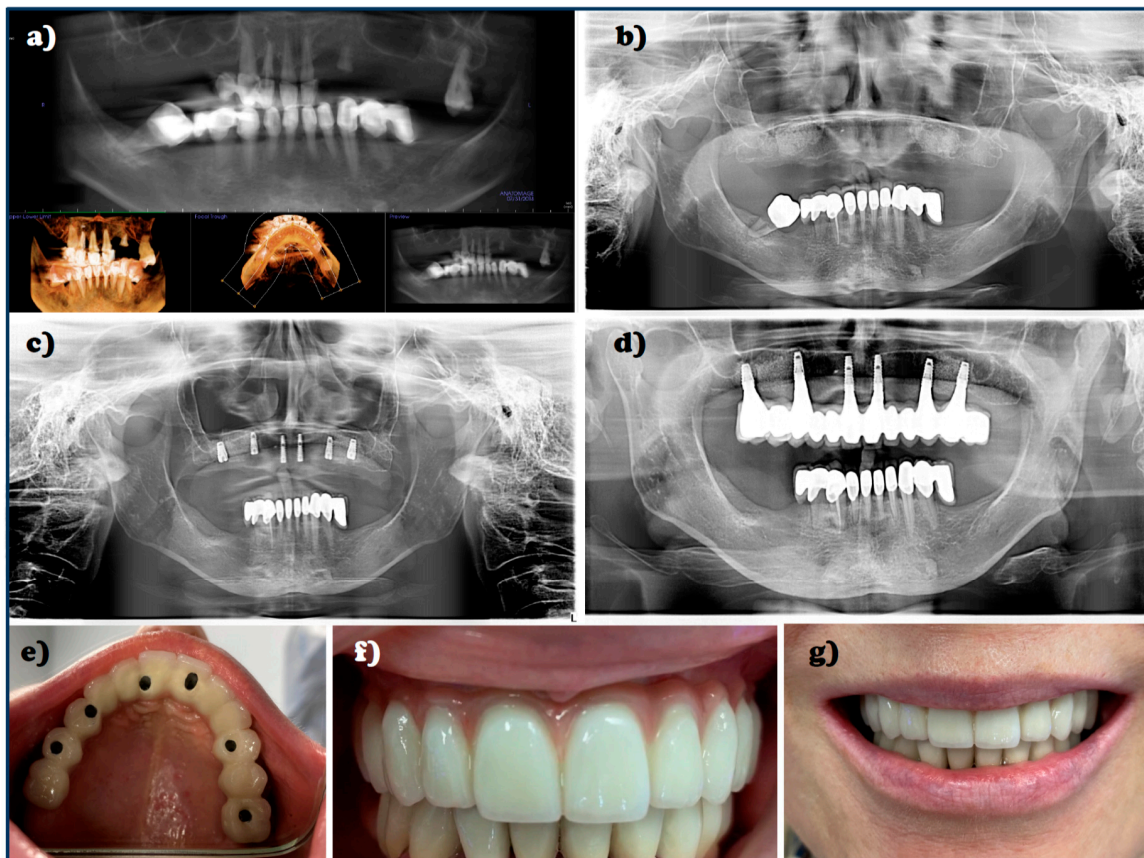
An example of an implant-prosthetics treatment of the female patient with 3-degree unstable (MOB = 3) prosthetic restoration of the 12–24 segment due to periodontal disease. (a–d) The pantographic X-ray images: (a) revealing significant bone loss; (b) after tooth extraction from periodontal diseases reasons; (c) after the insertion of the implants using a surgical template; (d) after installing the finished prosthetic restoration; (e–g) view of the prosthetic restoration: (e) in the oral cavity; (f) full-arch prosthetic bridge; (g) the patient’s full smile after treatment.
